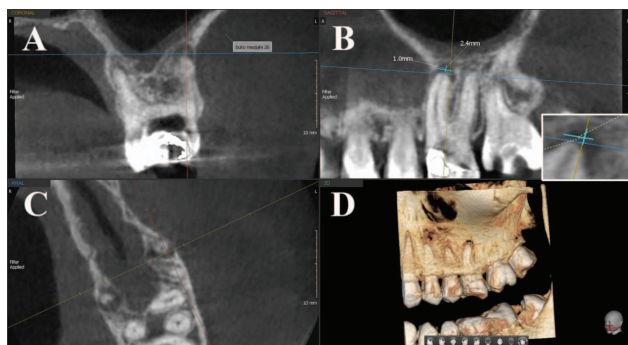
The images of one representative small-size periapical lesion (teeth 26): A) Sagittal cross-section (buccal and palatal root); B) Coronal cross-section (buccal root); C) Axial cross-section (root apex); D) 3D reconstruction – Dental Cone Beam Computed Tomography – CBCT. The insert represents a higher magnification of the measured lesion size.
